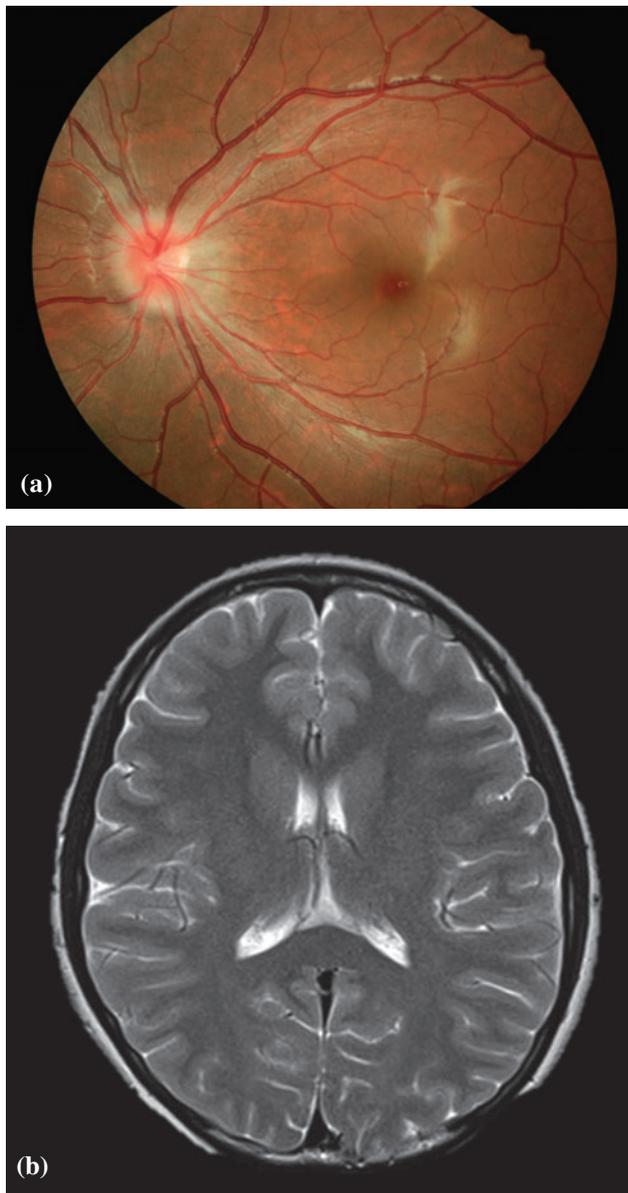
(a) Grade 4 papilloedema showing total obscuration on the disc of a segment of a major blood vessel on the disc. (b) Magnetic resonance image of brain showed normal size of ventricles.
